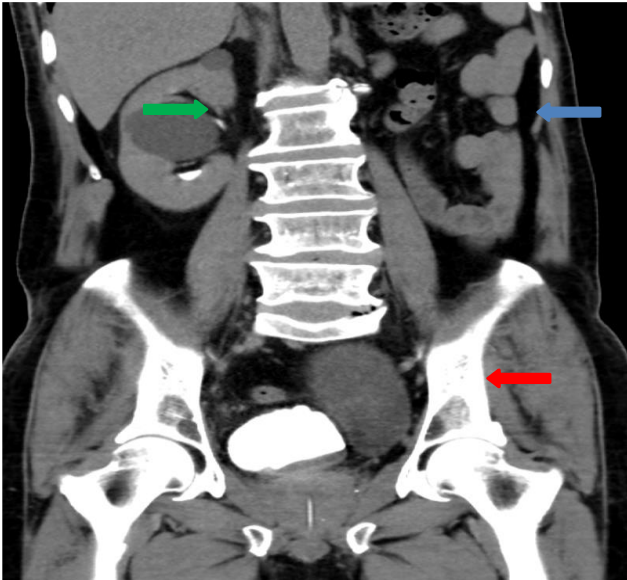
Coronal section of CT urogram of the patient showing cystic dilatation of the left seminal vesicle having well defined interface with the urinary bladder (marked in red arrow). Also note the absence of left kidney (marked in blue arrow) and a simple cyst in the interpolar region of right kidney (marked in green arrow).
